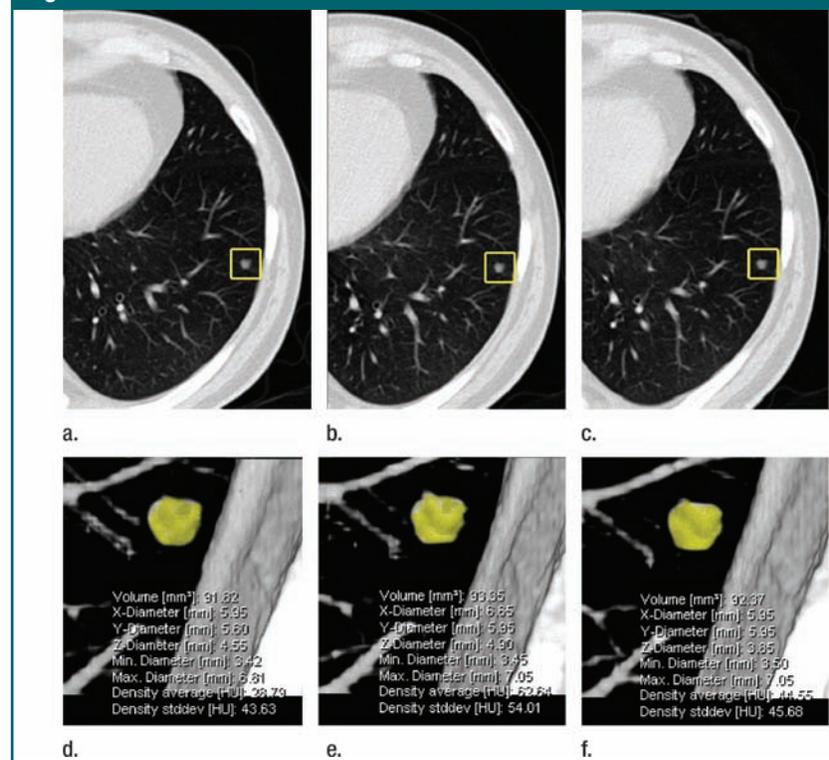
(a–c) Axial maximum intensity projections without contrast material at baseline, 3-month follow-up, and 12-month follow-up CT, respectively, and (d–f) respective volume-rendered images of 6-mm stable pulmonary nodule. Volume and diameter measurements were almost identical. Green boxes in a–c indicate nodules. Green areas in d–f indicate volume measurements.
